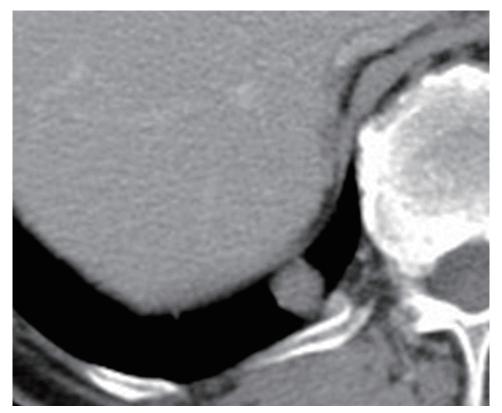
Preoperative chest computed tomography (mediastinal window)
